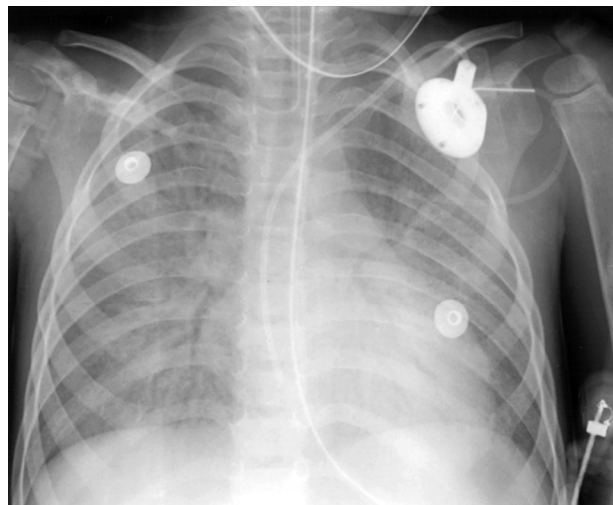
Chest radiograph of a patient with acute respiratory distress syndrome (ARDS). Note the infiltrates in all five lobes, the air bronchograms that appear as a result of areas of consolidation, and the loss of lung volume.
